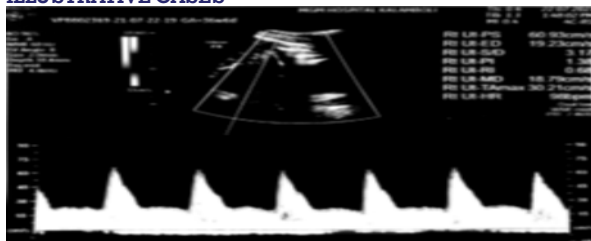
Abnormal right uterine artery Doppler sonogram
